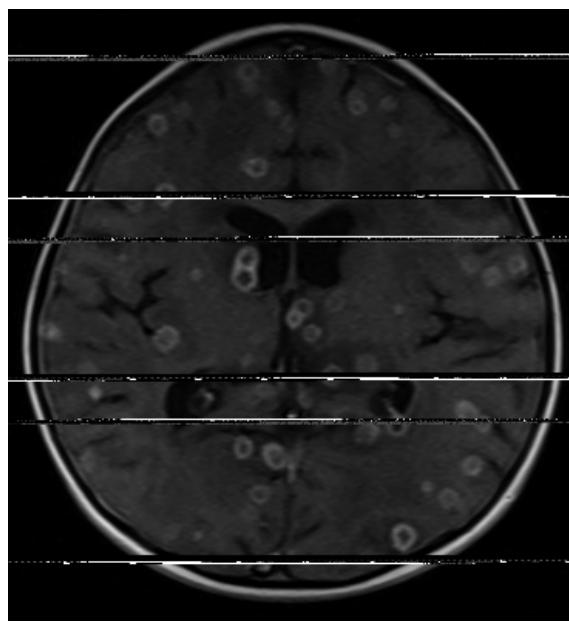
Magnetic resonance imaging of brain axial cuts showing intraventricular cysts.
